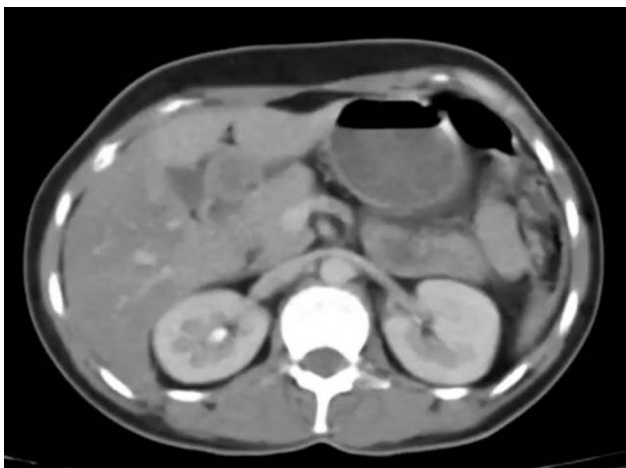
CT abdomen showing absence of pancreatic parenchyma except thin strips of tissue at the level of the head and uncinate process. CT, computed tomography.
